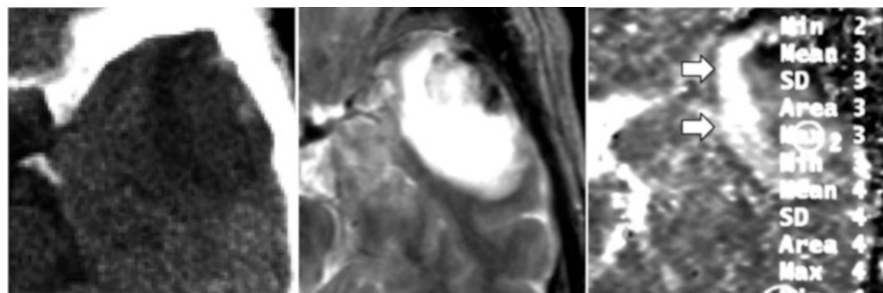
Cerebral contusion in the temporal tip at 45 h post-trauma. *Left:* CT scan showed small LD area in the temporal tip. *Middle:* T2-weighted MRI revealed mixed intensity area in the core of contusion and surrounding edema formation. *Right:* ADC mapping demonstrated a crescent-shaped zone (arrows) of very high ADC value, as high as that of CSF, representing edema fluid accumulation within the central area of contusion
